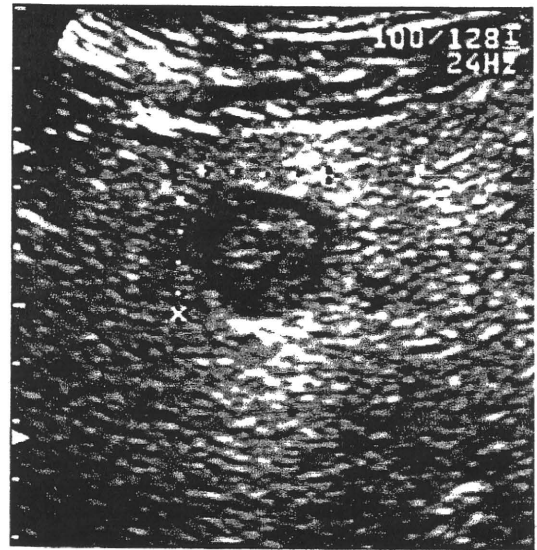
Ultrasonogram showed an iso- to hypoechoic nodule in segment VI. This largest nodule measured 20×21 mm. The echo pattern in surrounding liver parenchyma demonstrated fatty liver and associated chronic damage.
